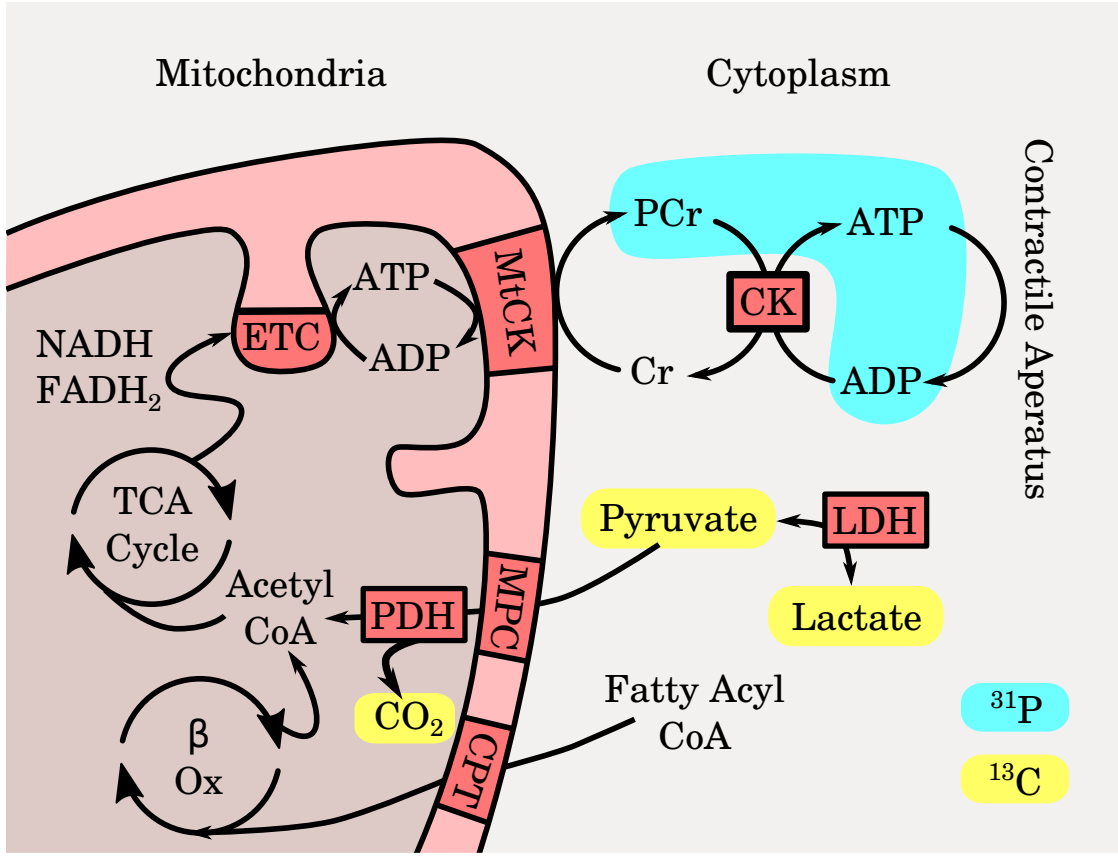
Summary of metabolism in the heart, with metabolites we can quantify through ¹³C and ³¹P MRI highlighted.
